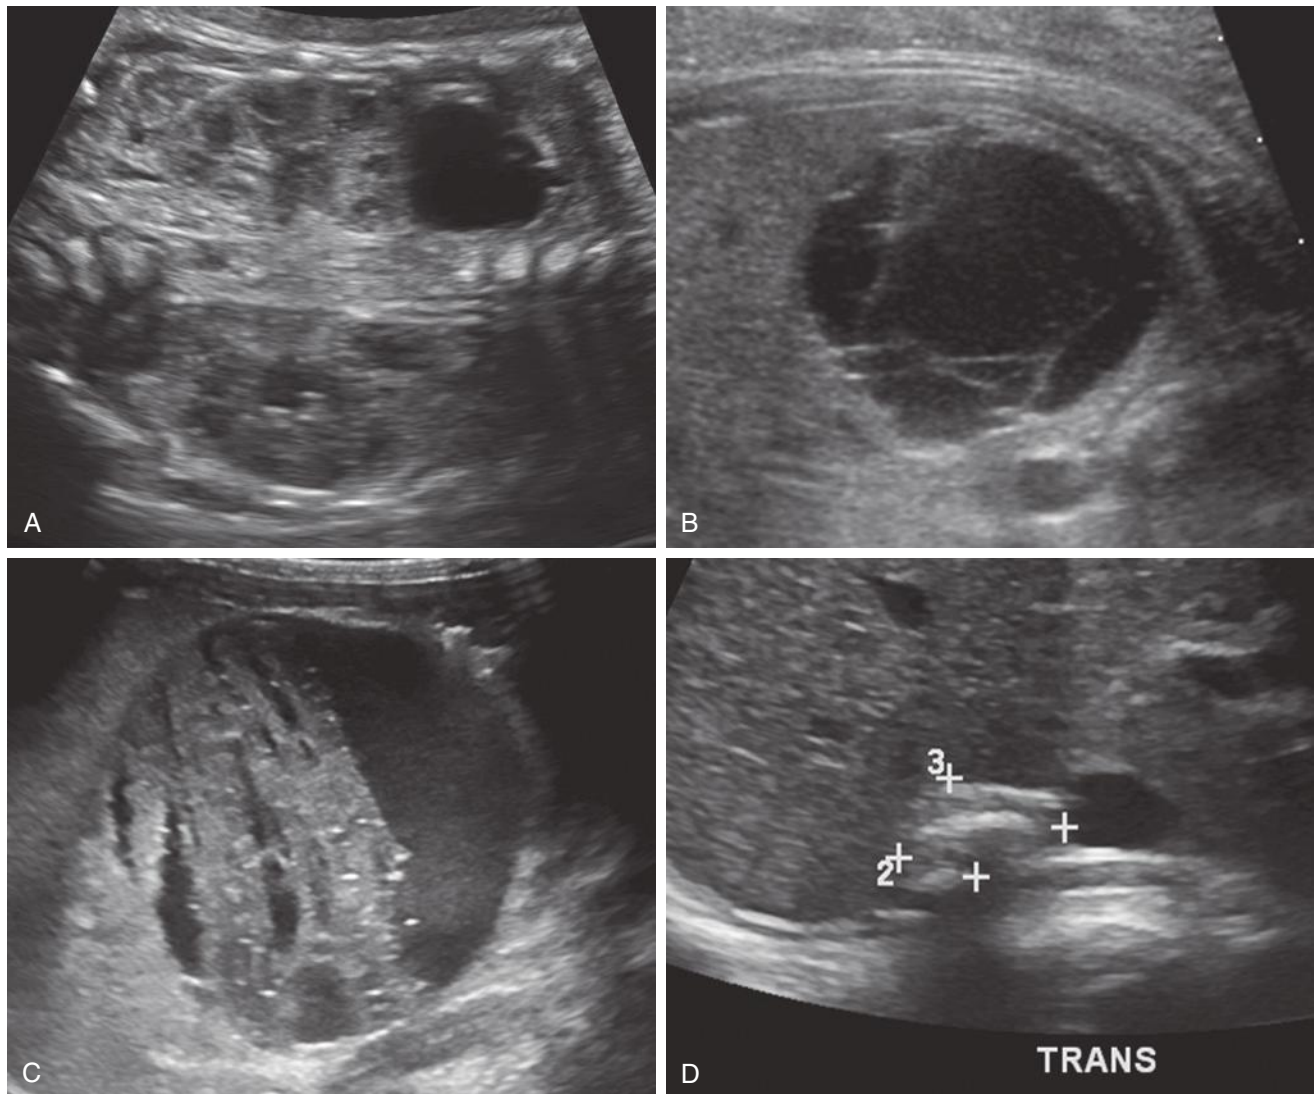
Adrenal neuroblastoma, cystic. A, Coronal sonographic image obtained at 31 weeks shows a thin-walled anechoic cyst cephalad to the right kidney. The bilateral kidneys appear normal with expected corticomedullary differentiation. B, Two weeks later, the mass appears slightly larger with internal echoes and strands suggesting hemorrhage. C, Transabdominal sonogram of the hemorrhagic cystic adrenal mass obtained shortly after birth. D, The child was managed conservatively with follow-up imaging. At 4 years of age, involution of the adrenal lesion (*calipers*) with calcification is shown.
